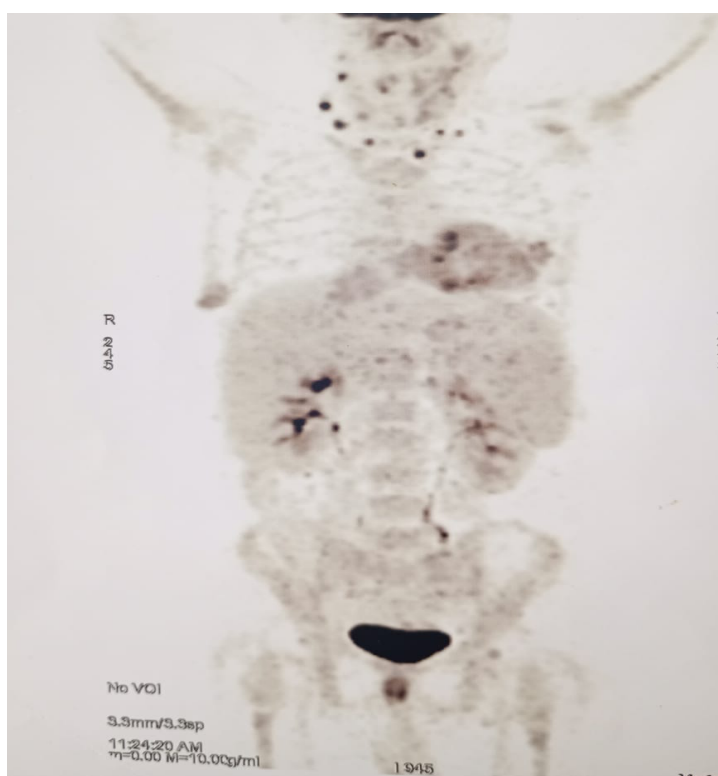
Whole-body FDG-PET/CT showed a metabolically active lesion in the right thyroid lobe and metastatic nodes in bilateral levels II, III and IV
